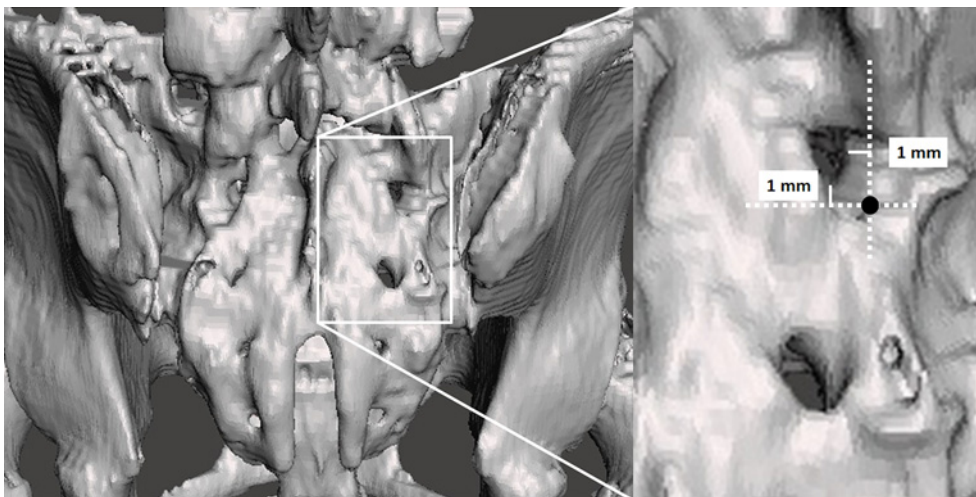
Entry point of the S2 alar-iliac screw (S2AIS) on a three-dimensional computed tomography image. We chose 1-mm distal and 1-mm lateral to the S1 dorsal foramen as the entry point of the S2AIS.
